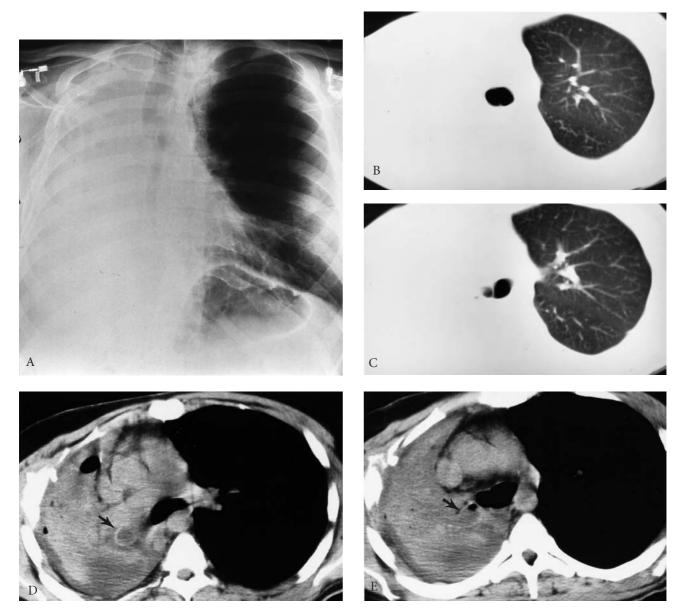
Subacute right main bronchial tear. A, Anteroposterior chest radiograph reveals complete opacification of the right hemithorax and shift of the trachea and mediastinum to the right, consistent with right lung collapse following contained laceration of the right main bronchus. Computed tomography scans with lung windows at the carina (B) and slightly below the carina (C) demonstrate narrowing of the lacerated right main bronchus. D,E, Soft tissue windows at the same levels reveal a fluid-filled, displaced distal right main bronchus (arrow).
